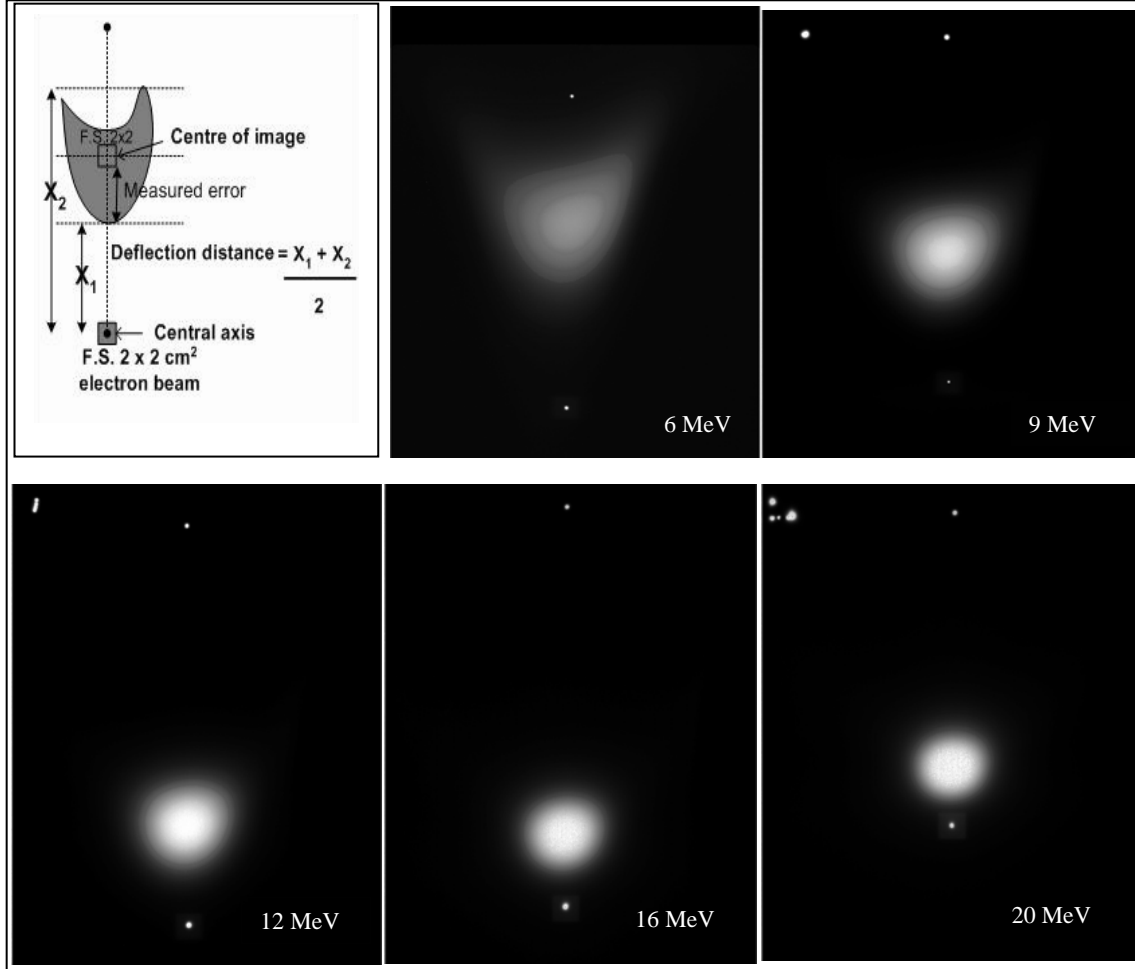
Radiographic images used to determine deflection distances of electron beams from 6 MeV up to 20 MeV after passing through the magnetic deflector device.
